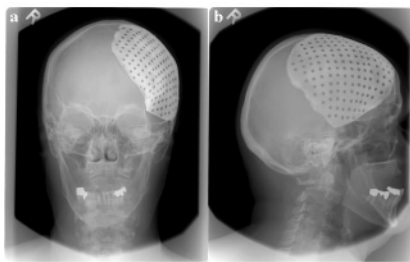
Anteroposterior (a) and lateral (b) radiographs obtained in a patient following frontotemporoparietal craniectomy for decompression.
